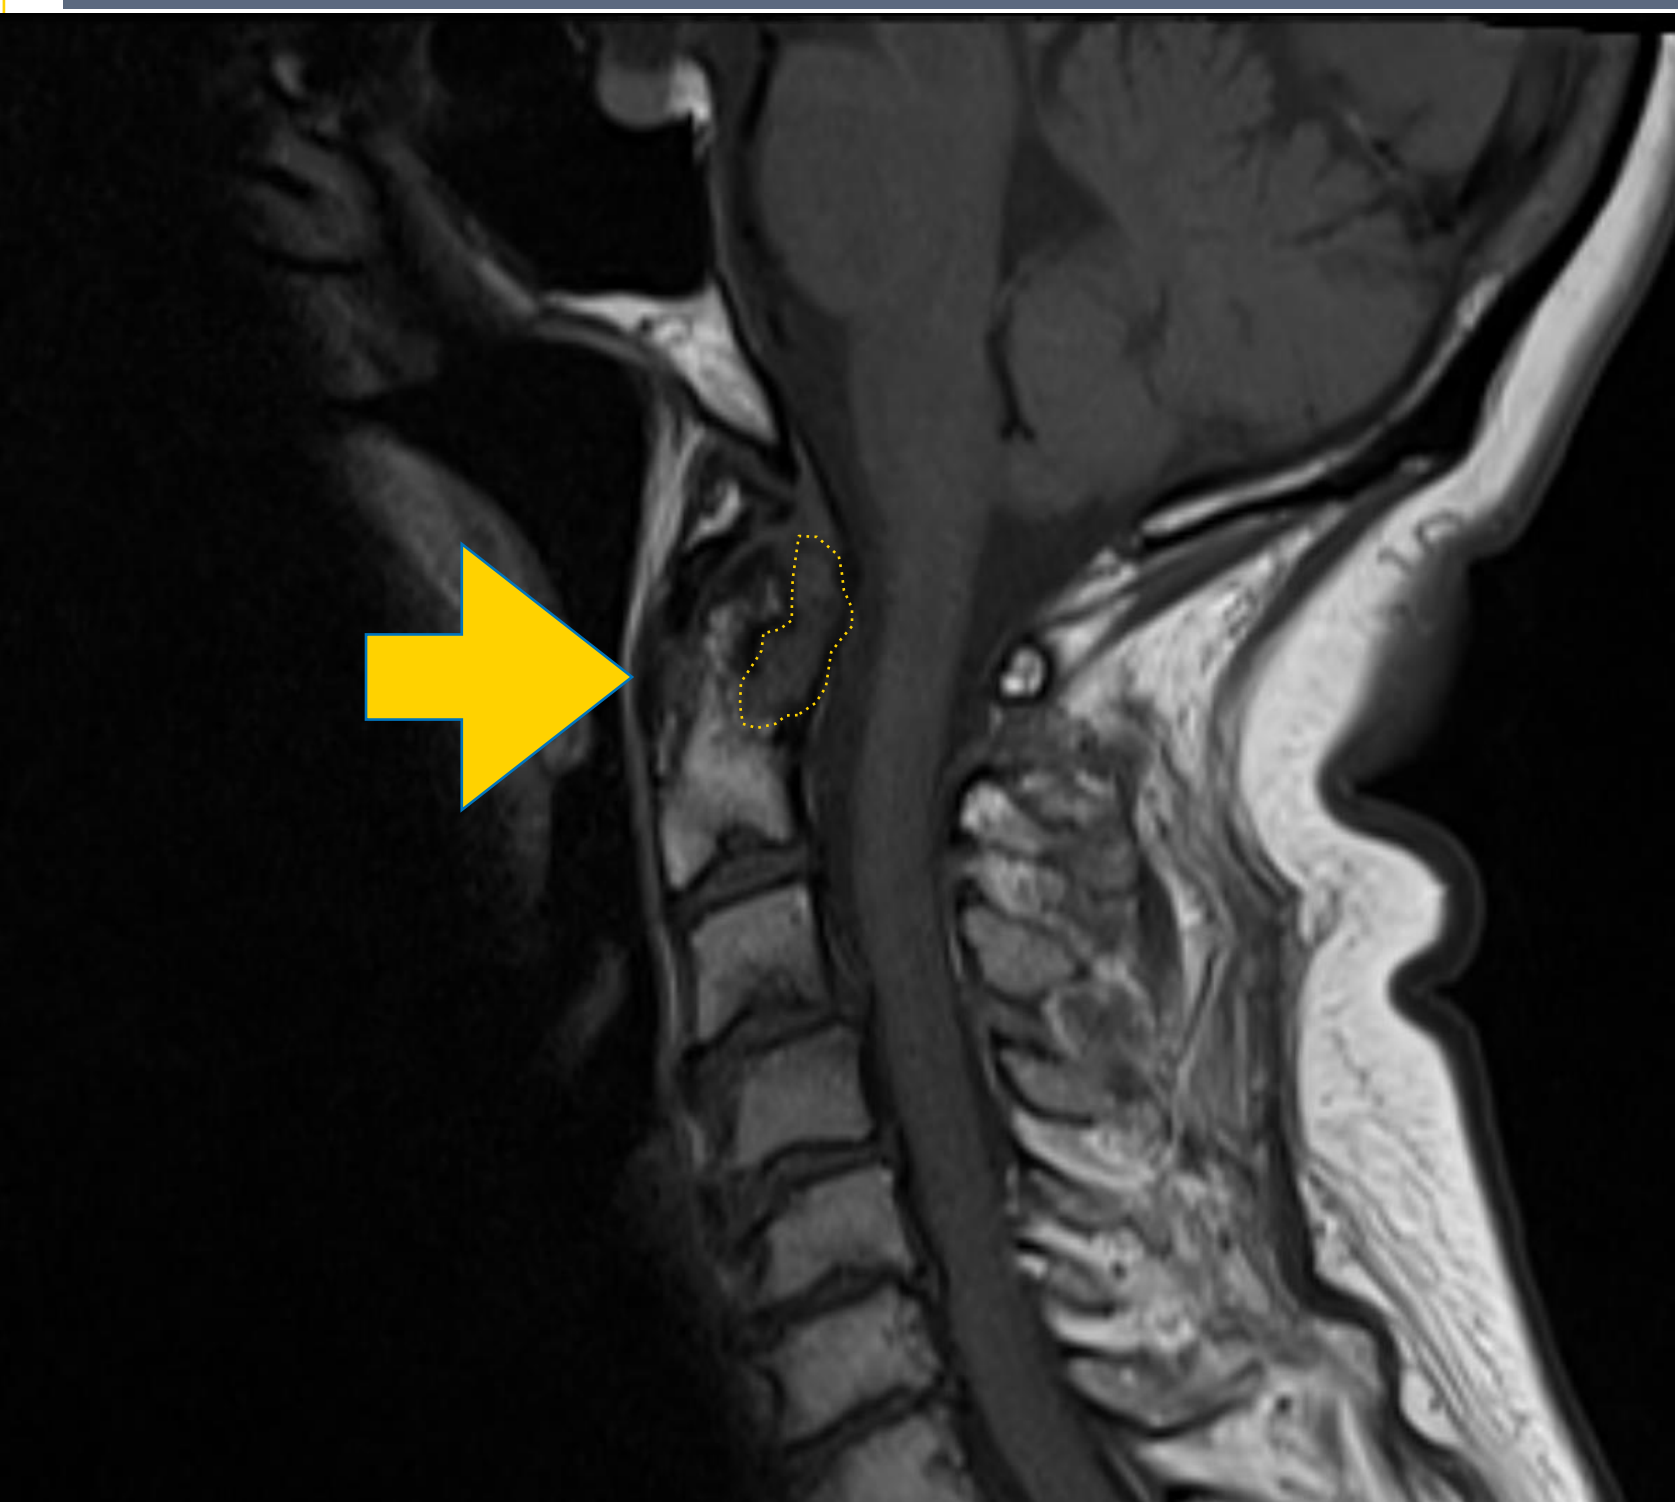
C-spine MRI (top left) T1 and (middle right) T2 show atlantoaxial pannus formation (yellow dotted shape) with moderate edema within C1-C2 (blue triangle) and erosion of the dens (yellow arrows).
